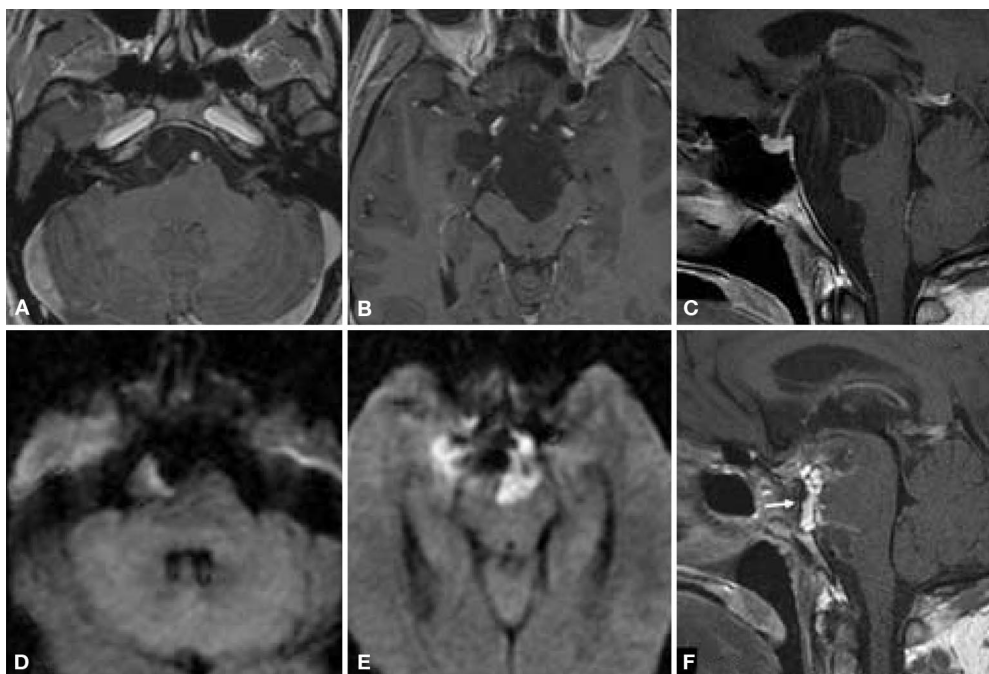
Sellar MRI scans of Patient 2. Preoperative axial (A and B) and sagittal (C) images after intravenous gadolinium diethylenetriamine penta-acetic acid: a large ventral brainstem mass centered in the interpeduncular fossa with anterior extension to the suprasellar cistern, with surrounding of the infundibulum, rightward extension into the right choroidal fissure, inferiorly to the pontomedullary junction on the right, and superiorly invaginating into the chiasmatic and infundibular recesses of the third ventricle. One-year postoperative axial DWI (D and E) and sagittal postgadolinium images (F) show residual tumor in the interpeduncular right prepontine cistern, right premedullary cistern, and along the right mesial temporal lobe. The titanium mesh buttresses used for the planum/suprasellar and clival bony defects are visible (arrow).
